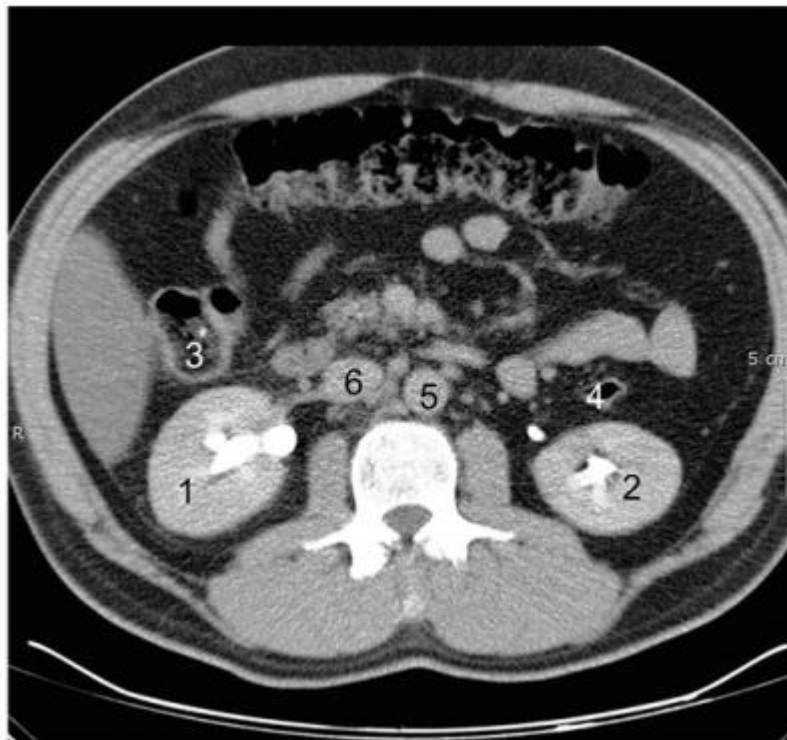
Abdominal CT scan at the level of kidneys in a patient in the supine position. 1: Right kidney; 2: Left kidney; 3: Ascending colon; 4: Descending colon; 5: Abdominal Aorta; 6: Inferior Vena Cava (Hopper et al., 1998).
